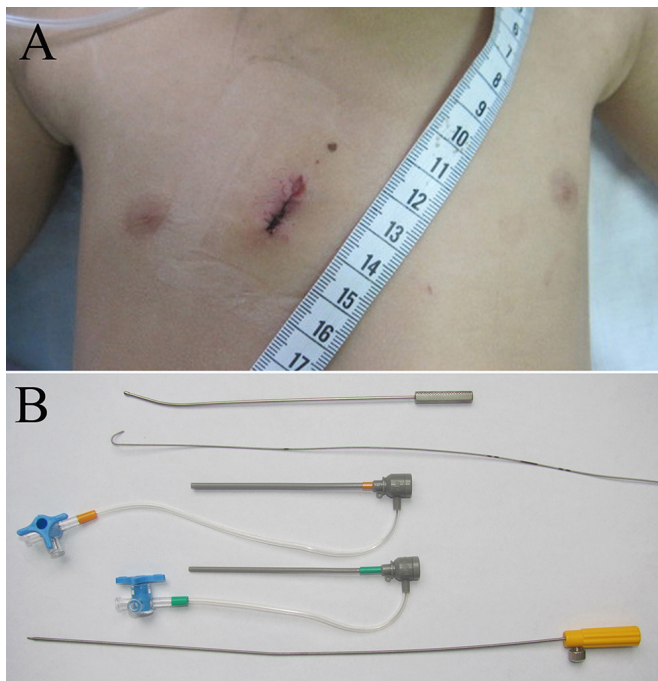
The right parasternal incision (A) and the probe-assisted delivery system (B), which consists of a J-tipped hollow probe, a flexible guidewire, a delivery sheath, a loader sheath and a delivery cable.
